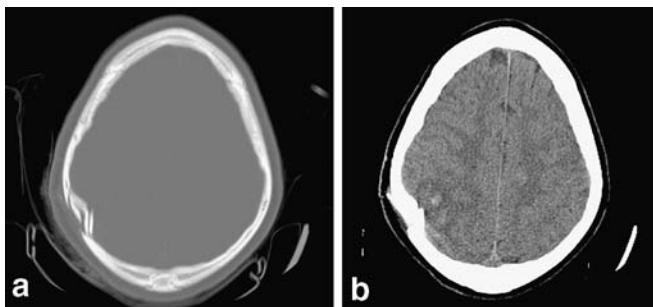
a Pre-operative head CT scan (bone window) demonstrating a depressed skull fracture secondary to a golf club impact; b pre-operative head CT scan (parenchymal window) demonstrating a depressed skull fracture secondary to a golf club impact
